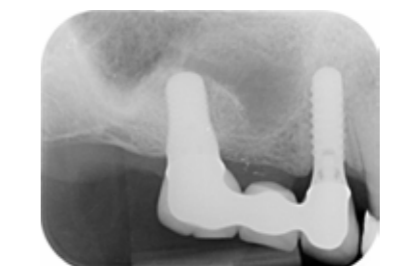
X-ray verification 7 years after surgery.
